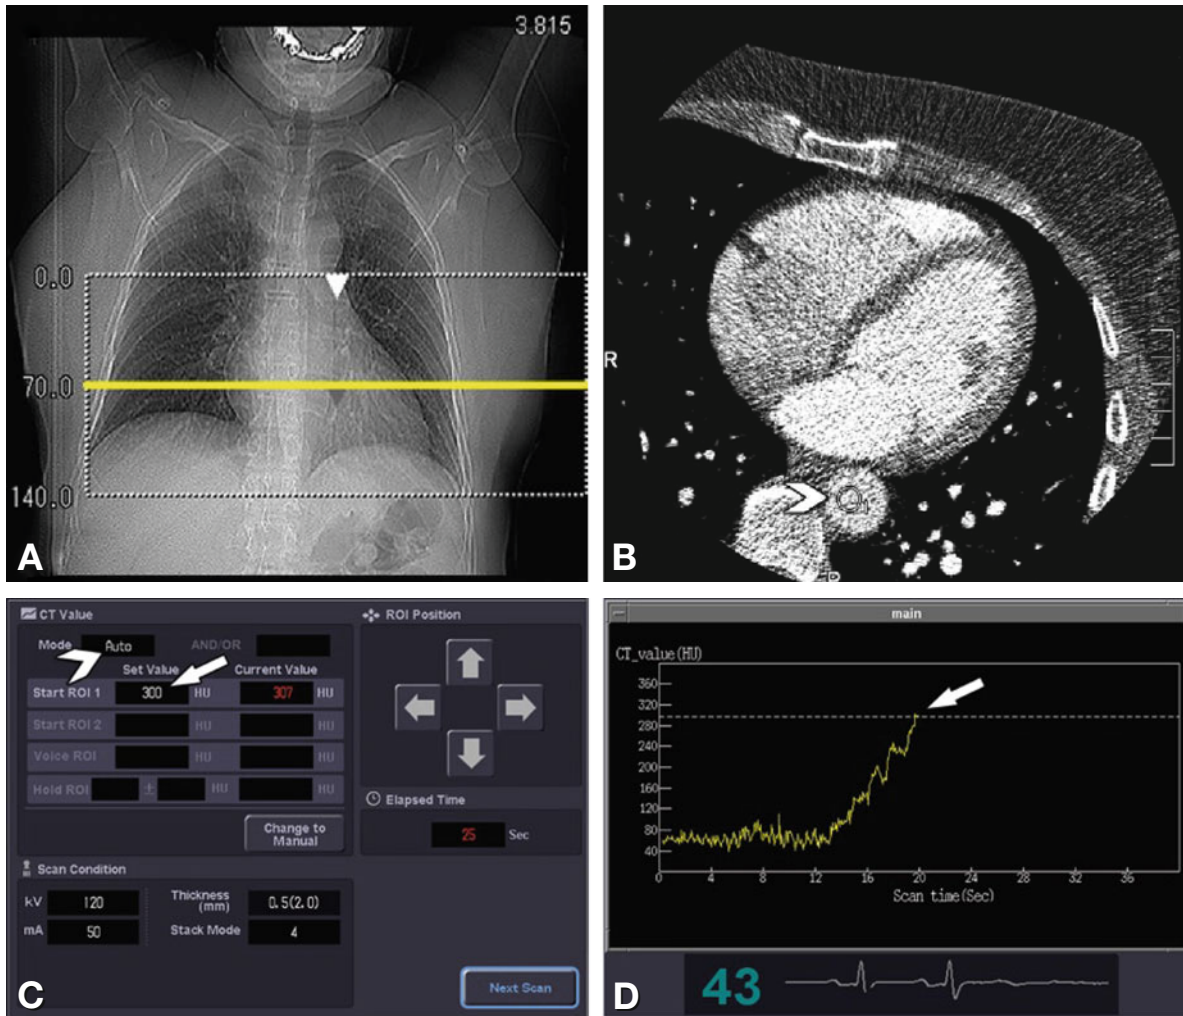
15 SureStart for 320-row CT. The low-dose scanogram is used to position the axial monitoring slice (Panel B) in the center of the scan area (Z-axis) (Panel A). This slice (Panel B) is used for real-time monitoring of the inflowing contrast agent, which can be followed on its passage from the right atrium and ventricle to the left atrium and ventricle, and to the thoracic aorta. The CT angiogram can be started automatically or manually. (1) Automatically starting the CT angiogram after a predefined attenuation threshold (HU) has been reached. Arrival of the contrast agent is measured in a region of interest (ROI) in the descending aorta (arrowhead) (Panel B). The ROI can be displaced from the aorta by respiratory motion while the SureStart scan is running, which must be corrected in order not to miss the optimal time for starting the CT angiogram. The position of the ROI (Panel B, arrowhead) can be corrected with the cursor (Panel C, right). When the predefined threshold is exceeded (Panel C, arrow), the scan is started automatically. The increase in HU measured in the descending aorta is presented online in the form of a Hounsfield unit curve, which serves as a control of contrast administration (Panel D). If the threshold is not reached, the scan can be started manually by clicking on the "Next Scan" button (Panel C). (2) Alternatively, the manual start option can be selected. When this option has been chosen, the user visually follows the inflow of the contrast agent on the monitor (Panel B) to start the scan. For this option, no threshold or ROI need to be defined. The scan mode is selected via the "Mode" button ("Auto" or "Manual," Panel C, arrowhead). In the manual mode, the CT angiogram is started by clicking on the "Next Scan" button (Panel C). The manual start option depends on the skills and experience of the operator but has a greater potential for reducing the amount of contrast agent administered. An optimal time point for starting the scan (automatically or manually) has been reached when there is good enhancement of the left ventricle and aorta and most of the contrast agent has been washed from the right ventricle (Panel B)
